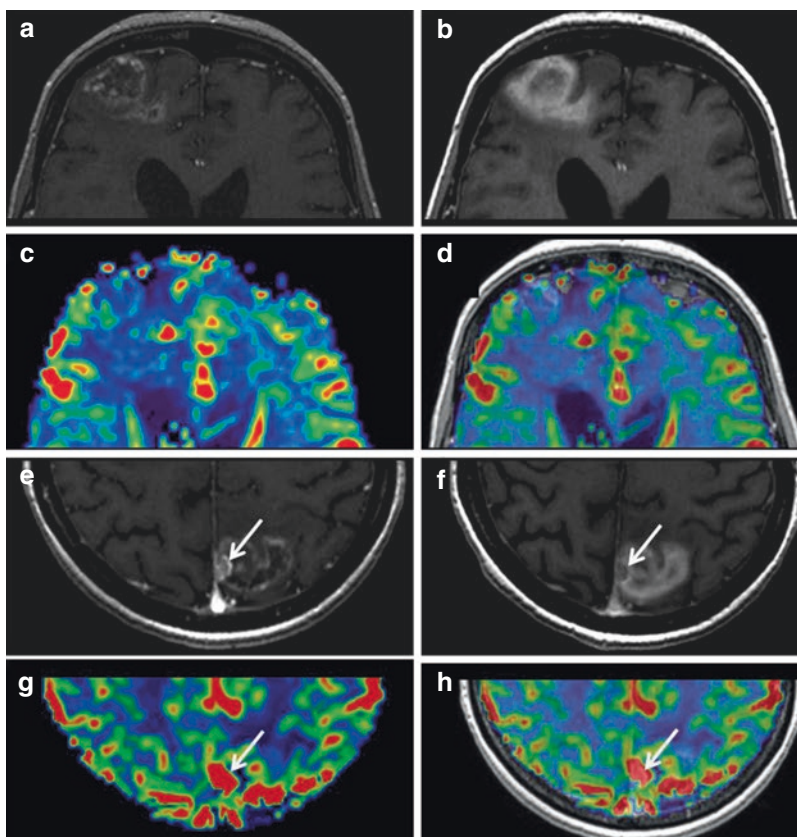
Differences in MRI between radiation necrosis and recurrence. Radiation necrosis is characterized by a ring-shaped enhancement on 3D T1 gradient-echo weighted images (3DT1-GE) (a) increased on delayed images acquired 75 min after gadolinium based contrast agent (GBCA) injection (b) with low relative cerebral blood volume (rCBV) (c). Image d represents the merging of images a and c to check the co-location of the enhancement and the low rCBV. Recurrence
